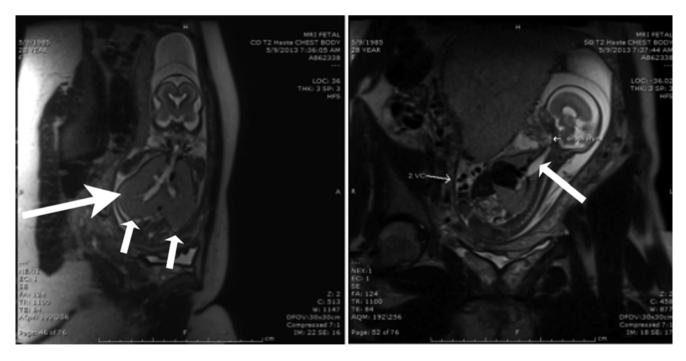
Fetal MRI images in coronal and sagittal planes demonstrating the characteristic features of CHAOS due to complete obstruction of the larynx due to a laryngeal web; the *large arrow* is pointing at the very
